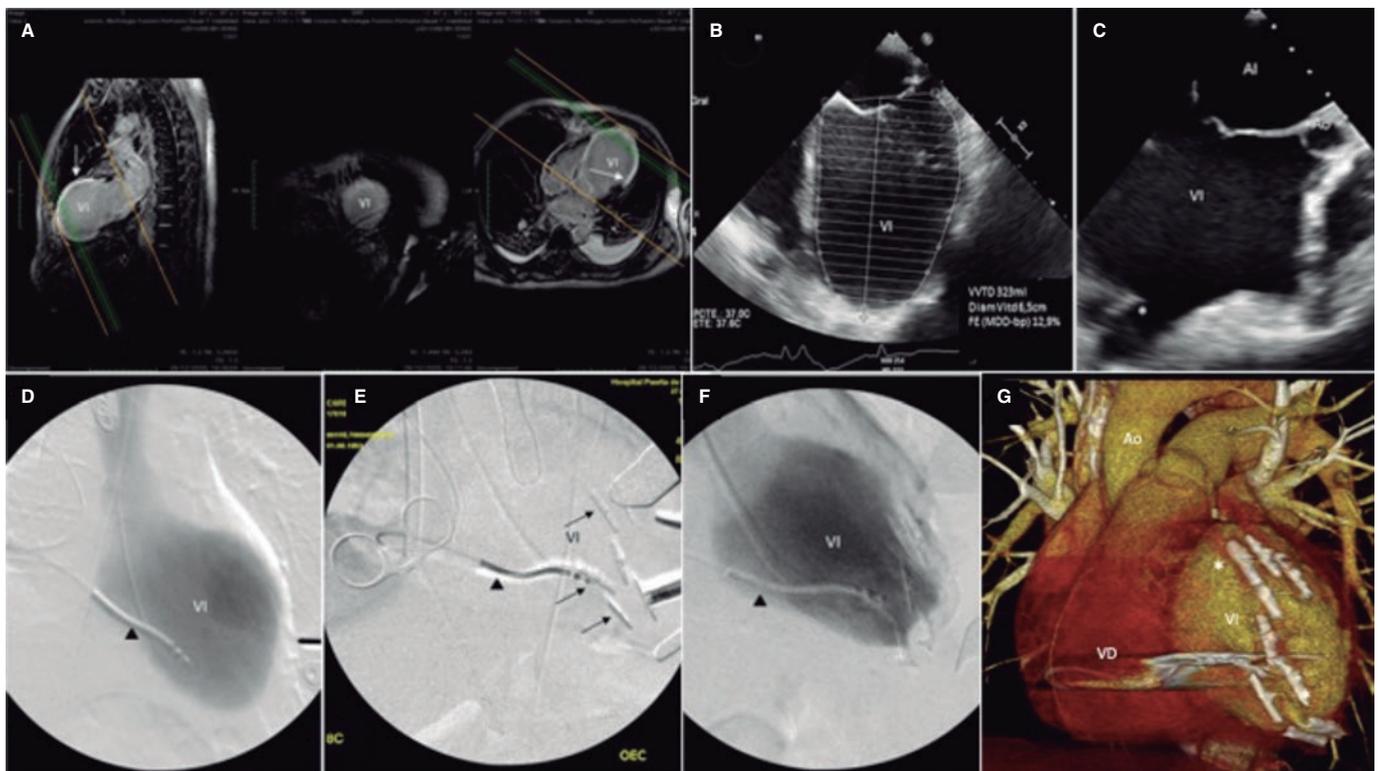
A: preoperative magnetic resonance imaging. Two-chamber long axis view, and 3-chamber long axis view, ischemic scar (arrows). B: preoperative transesophageal echocardiography (TEE), 4-chamber view, LV end-diastolic volume. C: intraoperative TEE, 3-chamber view, remodeled LV chamber, first anchor. D: intraoperative fluoroscopy, ventriculography, implantable cardioverter-defibrillator leads (arrowhead). E: reconstruction anchors (arrows). F: ventriculography final outcomes. 3D CT scan reconstruction. G: Final outcomes (asterisks). Ao, aorta; LA, left atrium; LV, left ventricle; RV, right ventricle.
